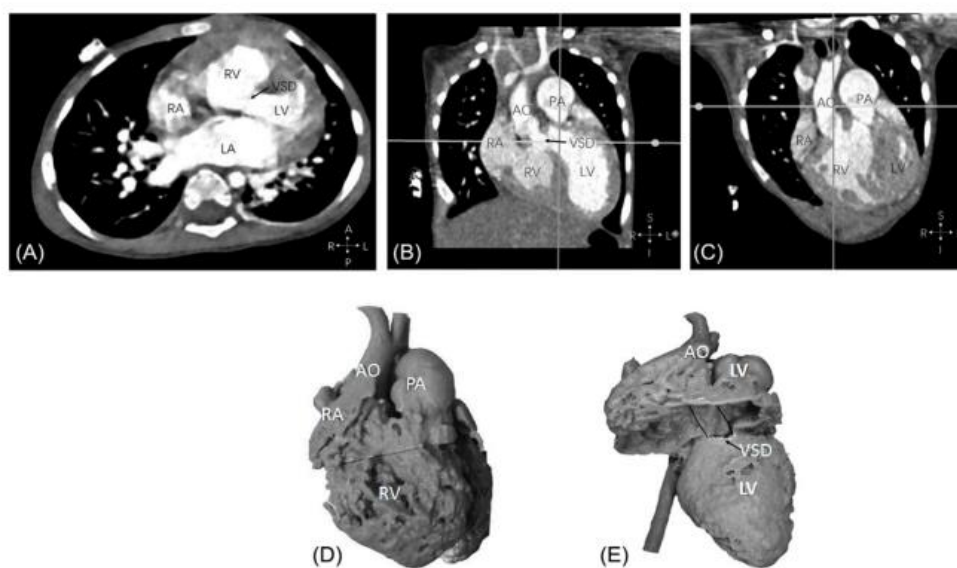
Example of double outlet right ventricle with aorta and pulmonary artery arising from the right ventricle and perimembranous ventricular septal defect from computed tomography images (A–C). Anterior view of the 3D printed heart model, aorta, and pulmonary artery are side-by-side with both arising from the right ventricle (D). Perimembranous VSD remotored from the arteries. Position of potential intracardiac tunnel from the left ventricle to the aorta is shown as the solid lines (E). AO—ascending aorta; LA—left atrium; LV—left ventricle; PA—pulmonary artery; RA—right atrium; RV—right ventricle; VSD—ventricular septal defect. Reprinted with permission from Zhao et al. [32].
